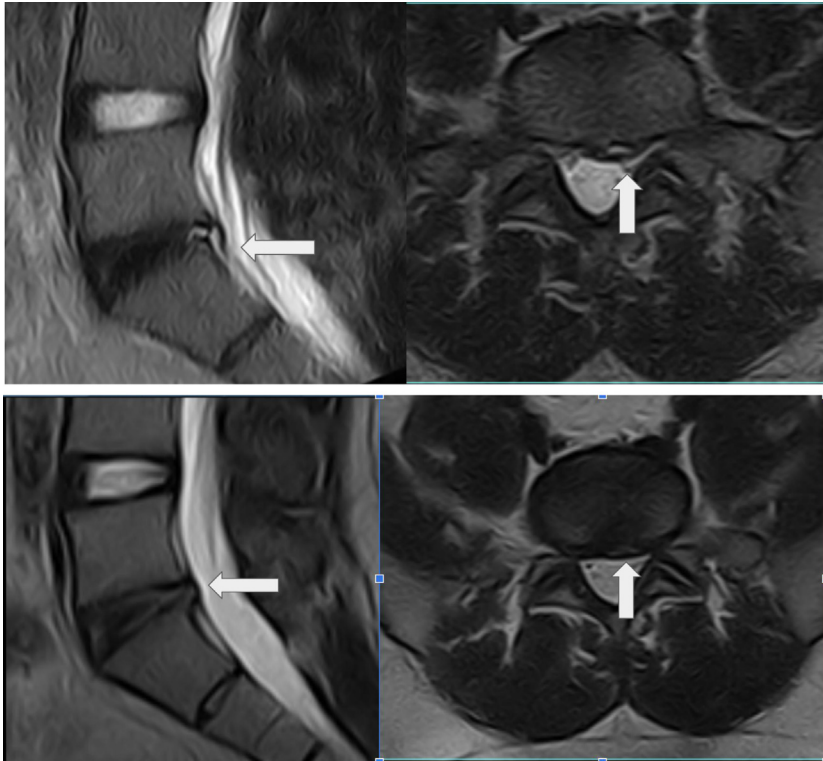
These are magnified T2 sagittal and axial MRI images of lumbar spine from a patient who received intradiscal LR-PRP treatment. The images on top are before treatment and the images on the bottom are from 3 months after LR-PRP treatment. The images reveal structural improvement in the large annular fissure and a reduction in the size of the left-sided protrusion
